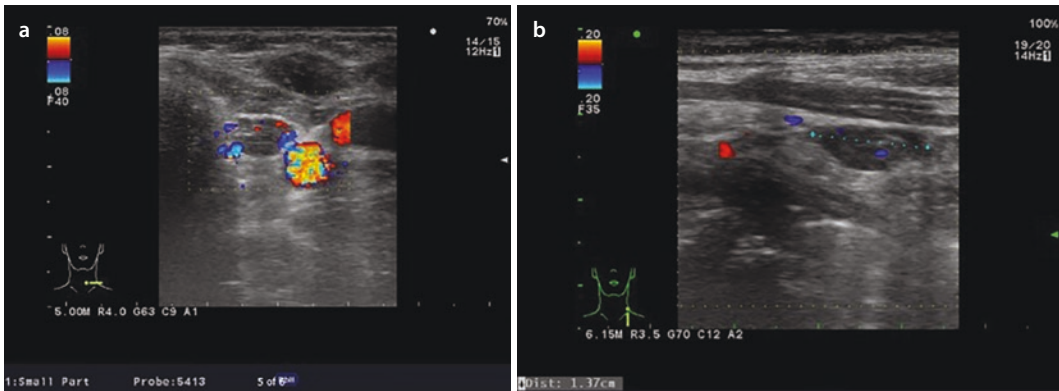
Ultrasound imaging of classic parathyroid adenoma. Ultrasound imaging of a classic left lower parathyroid adenoma lying posterior to the inferior pole of the thyroid. Increased vascularity can be seen in the transverse a and sagittal b planes
